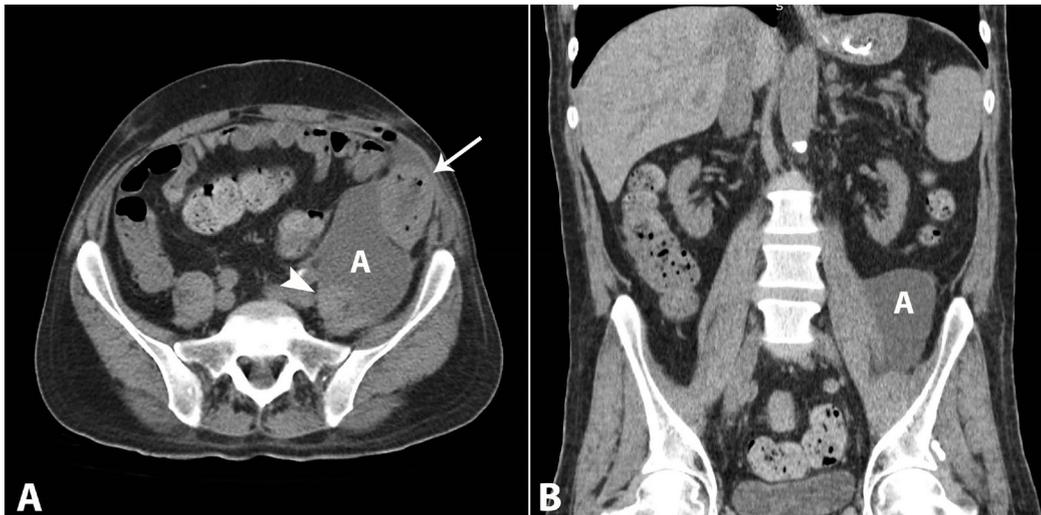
Abdominal CT images. A – Axial image: the graft surrounded by inflammatory process and gas (arrow) in contact with an abscess (A); perigraft abscess in close contact with the psoas muscle (arrowhead); B – Coronal plane. Note the abscess juxtaposed to the psoas muscle.
